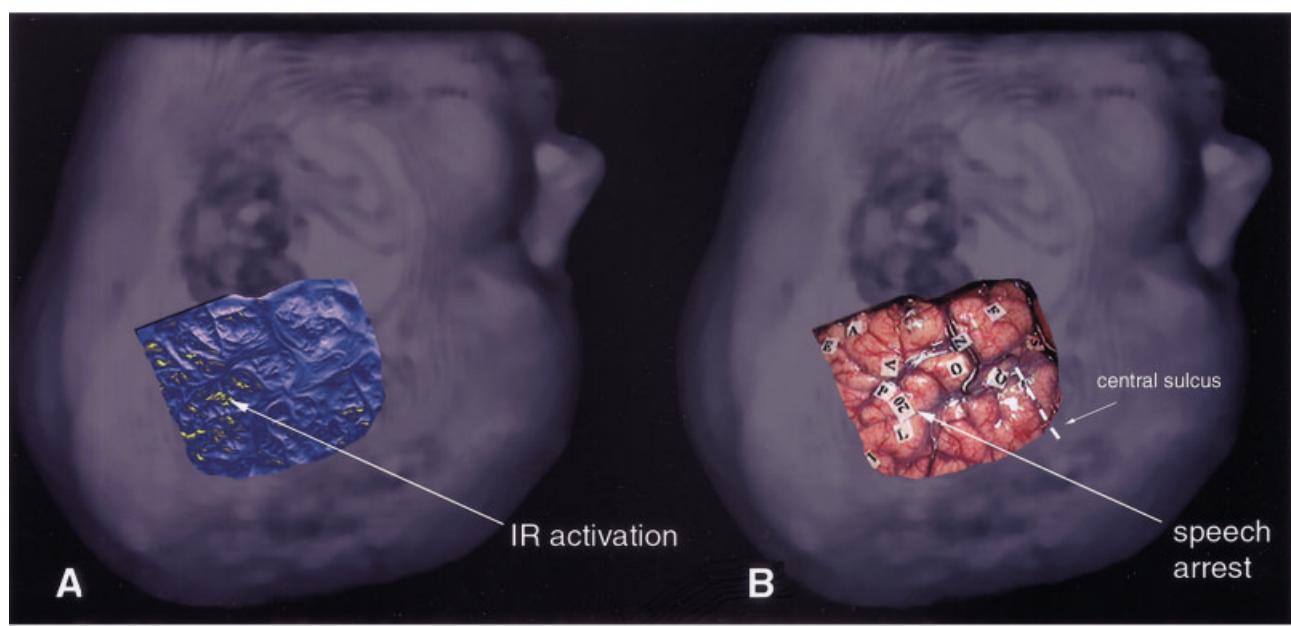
Functional infrared (IR) image of the brain during naming an object (verbal task). The IR image with maximum signal intensity was chosen among 100, registered, and layed over an magnetic resonance imaging–derived three-dimensional image of the patient's head (Patient 16). Note that the site of the maximum intensity of the IR signal (yellow, A) and the site where intraoperative cortical stimulation evoked speech arrest (Wernicke's area, ticket 20 on exposed cortex, B) have the same location. Note activation of additional cortical areas during naming (A).
